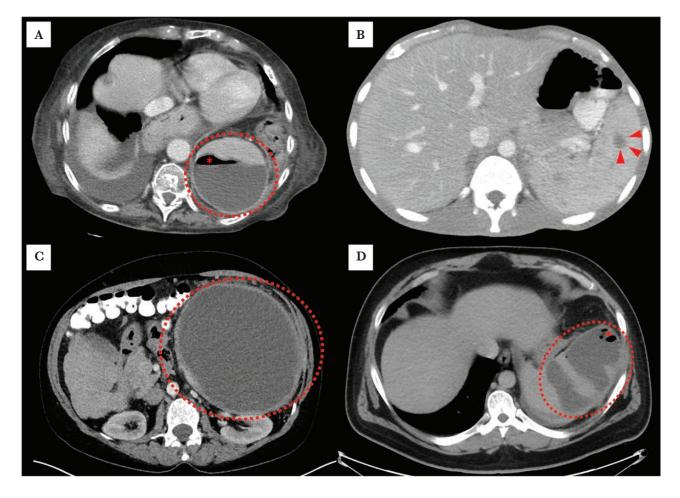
Representative computed tomography scans of splenic abscesses. A, Polymicrobial case in an 83-year-old woman with low-grade follicular lymphoma and pancreatic cancer. An abscess (interrupted circle) with an air–fluid level (asterisk) is visualized. B, Splenic histoplasmosis in a 30-year-old man with HIV. Arrowheads denote a 1.4-cm abscess. C, Coagulase-negative *Staphylococcus* case in a 62-year-old woman with cirrhosis and post–essential thrombocytosis myelofibrosis. An abscess (interrupted circle) is visualized. D, *Escherichia coli* case in a 40-year-old man with acute promyelocytic leukemia. A complex abscess (interrupted circle) with internal foci of gas (asterisk) is present.
